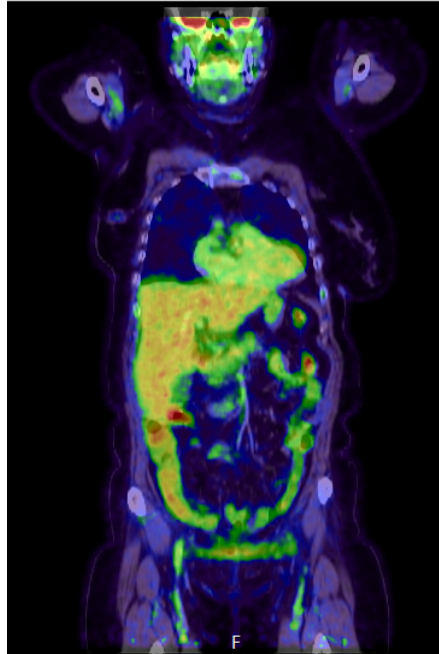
An example of a PET/CT image, depicting the patient from the skull to the mid-thighs.
